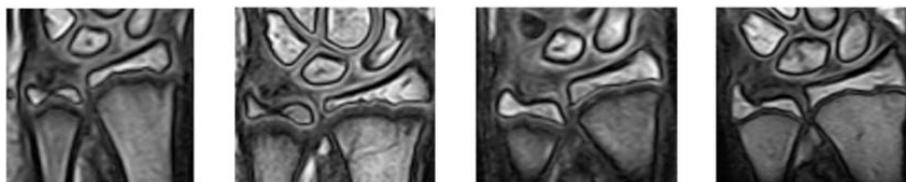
The development of the radial bone as observed in MRI-slices for four subsequent stages. Images from the University of Rome (Tomei et al., 2014).
